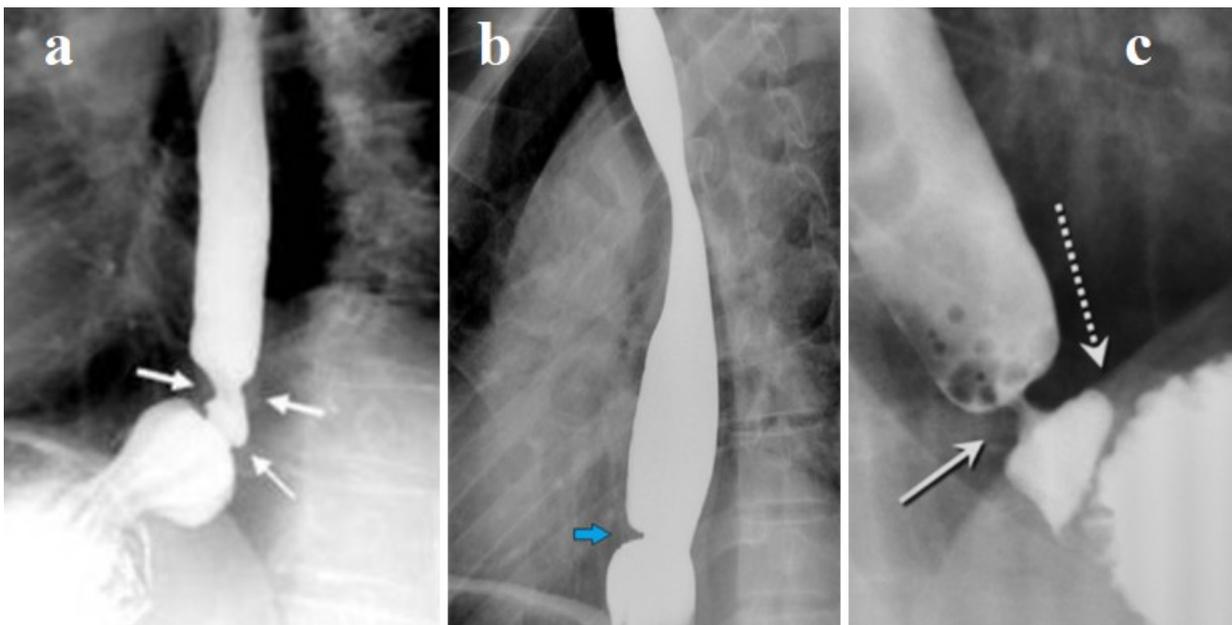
Radiographs from various articles described as examples of SR. (a) During the gag reflex, an asymmetric and long stricture above the short LES is visible (b) A 37-year-old woman with a history of GERD for more than 5 years with good symptomatic PPI control developed dysphagia. On the radiograph and on the endoscopy image, pronounced asymmetry of the ring is visible [12]. (c) Asymmetric stricture is near the short LES. Erosions are visible in the extended esophagus above the narrowing.
